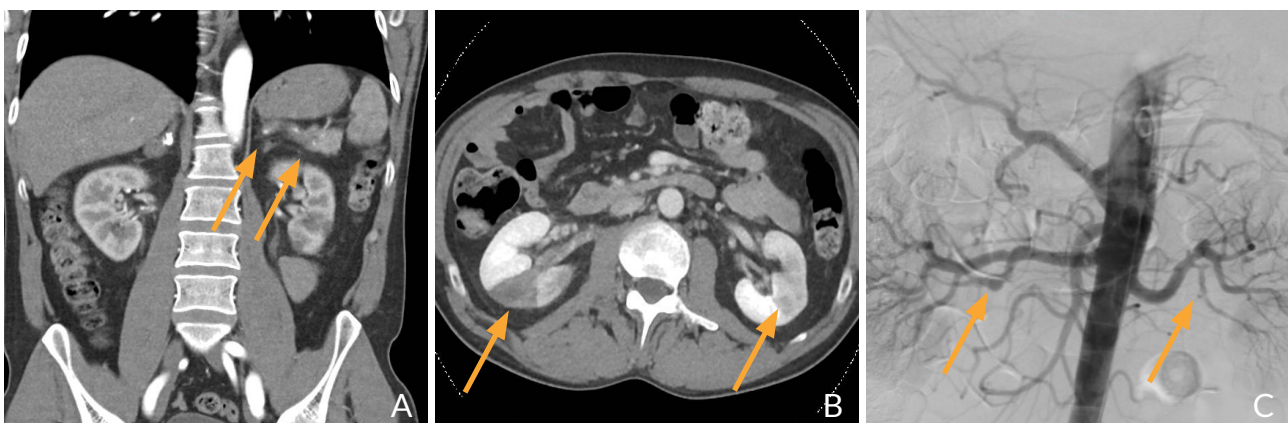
A: Early arterial phase CT shows the major circumferential hypodense thickening of the splenic artery (arrows). B: Late arterial phase CT reveals infarction of both kidneys (arrows). C: Arteriography demonstrates an alternation of dissections and aneurysmal dilatations of the renal arteries in their medial portions (arrows).
